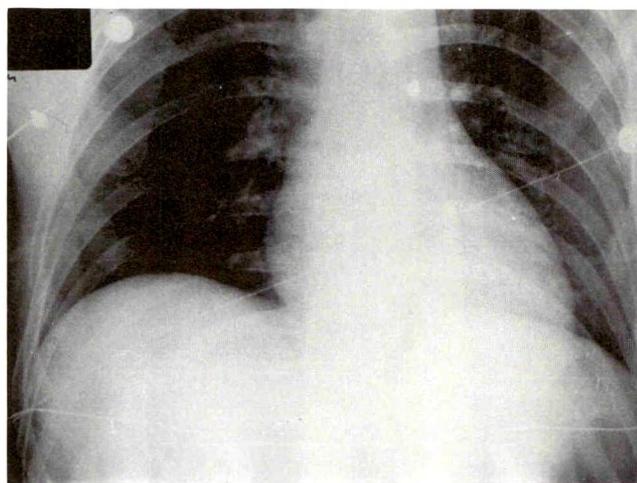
Admission chest x-ray revealing clear lung fields.
